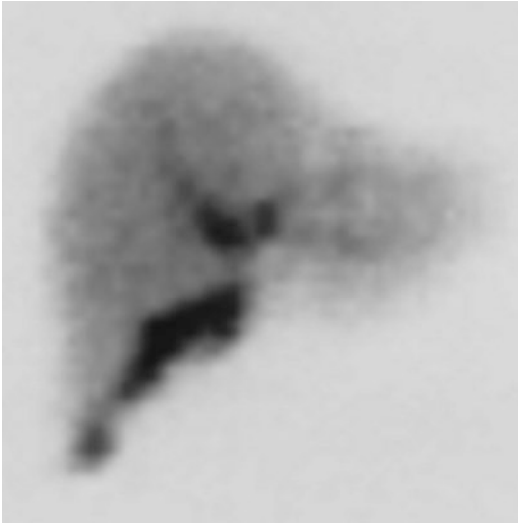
Isotope hepato-biliary scintigraphy shows extrabiliary isotope activity indicating bile leak; in today's clinical practice it is a sensitive investigation to rule out bile leak
